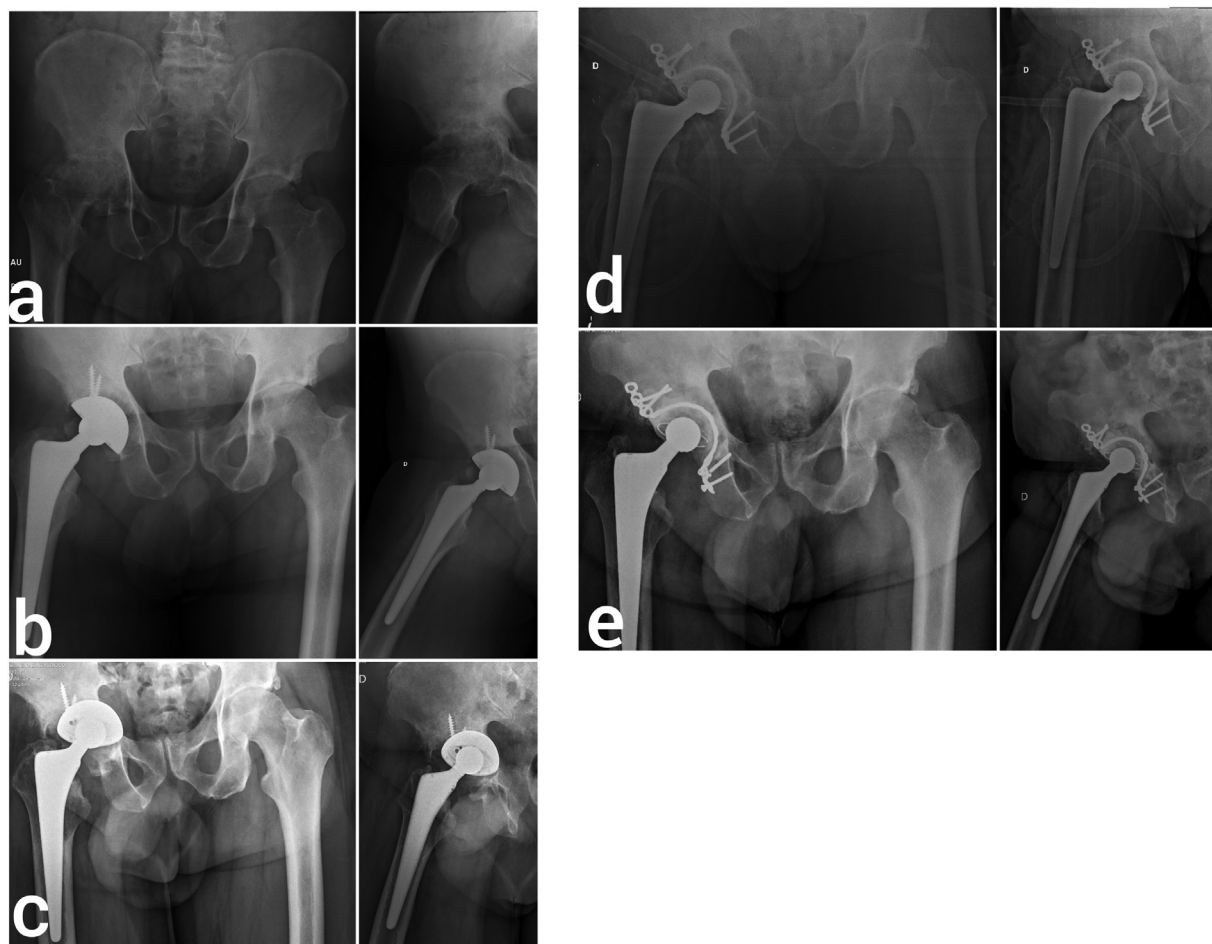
(A) Preoperative radiograph evidencing important osteoarthritis in the right hip (case 2). (B) Immediate postoperative radiograph. (C) Postoperative radiograph 15 years later, with Paprosky type-3B failure. (D) Immediate postoperative radiograph of the revision surgery. (E) Postoperative radiograph with two years of evolution, evidencing osteointegration of the graft in the acetabular fundus.
